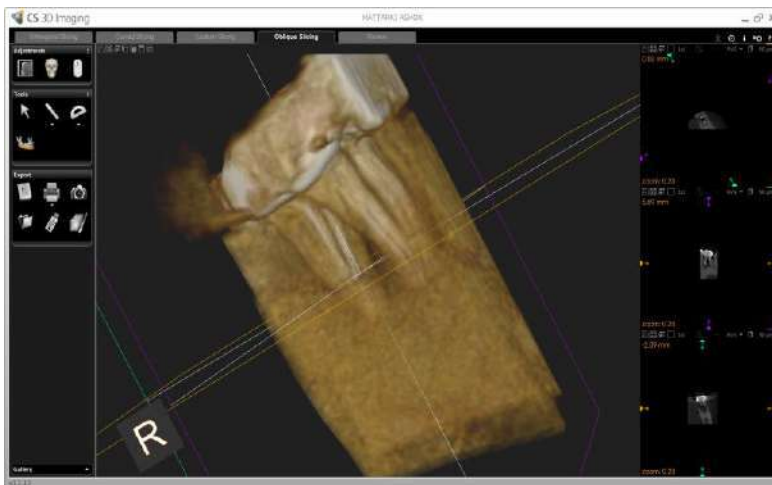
3.3 CBCT image showing oblique section and fracture on mesial root Courtesy Dr. Nair
